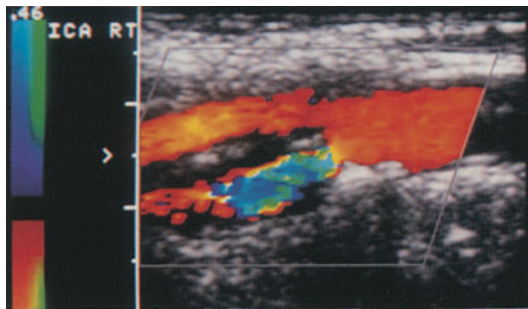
Longitudinal sonogram of carotid bifurcation demonstrates a small, homogeneous, thorn-like plaque on the posterior wall with marked flow disturbance downstream from the plaque
